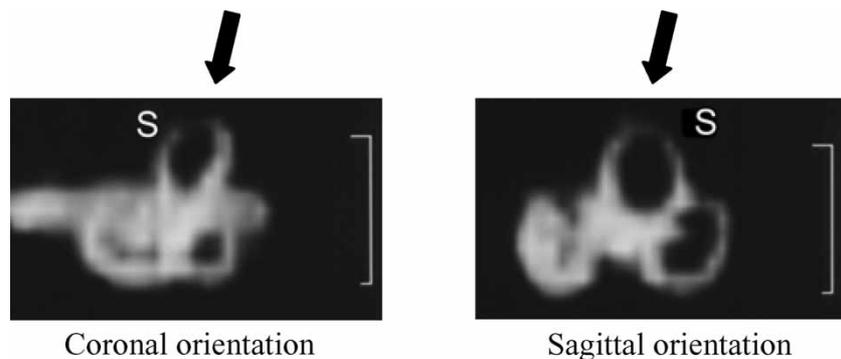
Case 3. HR-3D-MRI scans of the left inner ear (coronal and sagittal orientations) showing a 2.2-mm long filling defect (arrows) of the superior semicircular canal. For explanation of abbreviation, see Figure 1.
